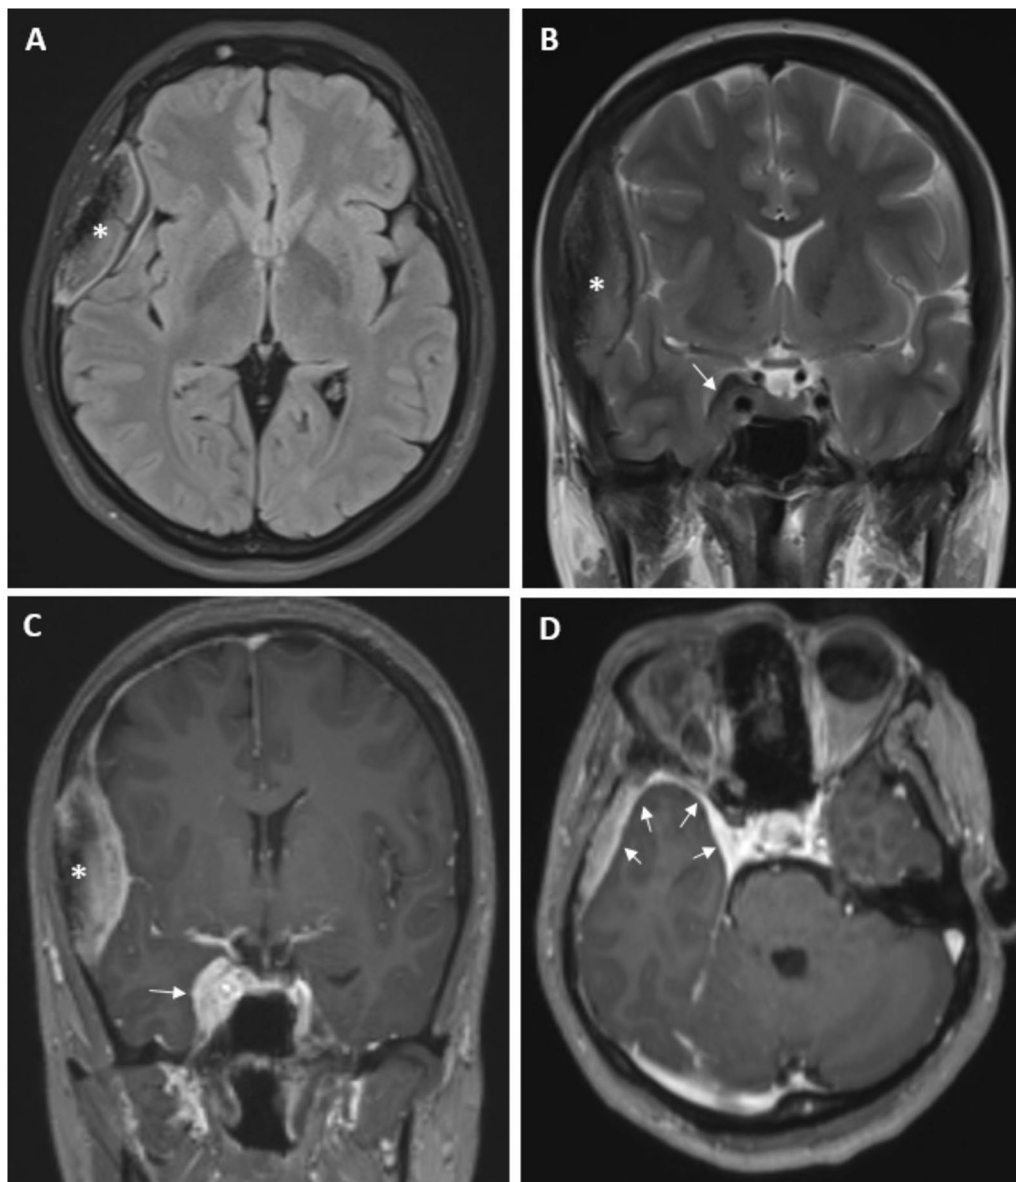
In the FLAIR sequence, on the axial sectional brain MR image (A) and in the coronal section T2-weighted image (B), a right frontotemporal lesion of heterogeneous intensity located at the distance of the diploe is observed (asterisks). A hypo-isointense lesion filling the right cavernous sinus is seen in the coronal section (white arrow). Coronal (C) and axial (D) section post contrast T1-weighted images show the continuity of the enhancement in the bone lesion along the dura and homogeneous intense enhancement in the right cavernous sinus
